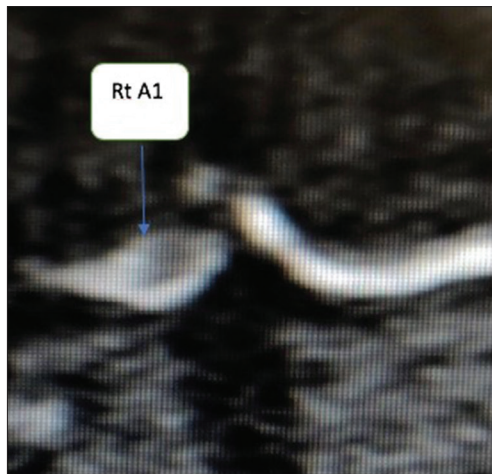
Contrast magnetic resonance imaging brain showing contrast enhancement on the wall of fusiform aneurysm segment of the right A1 anterior cerebral artery (blue arrow)
